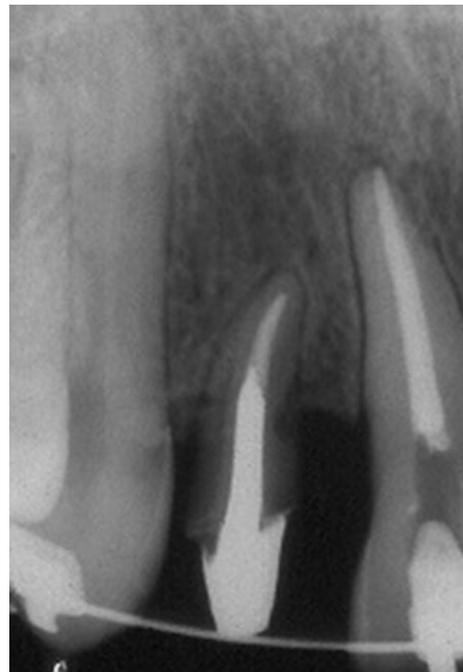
Radiographic follow-up of 12 months. The patient was having orthodontic treatment to correct the reverse articulation.
